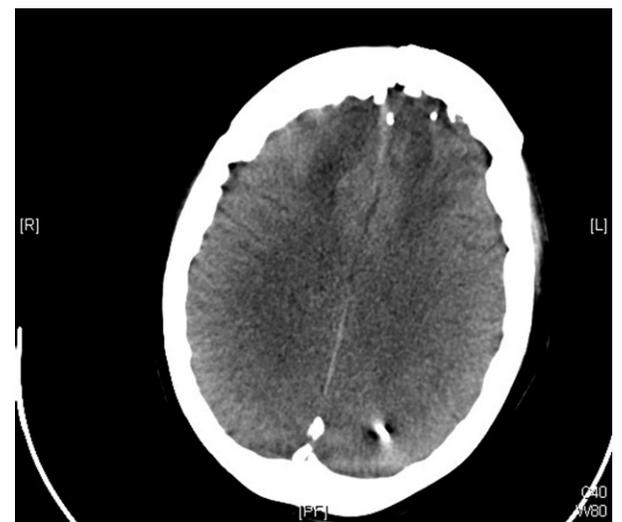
Axial CT image showing fragments of bullet in left high parietal region.
